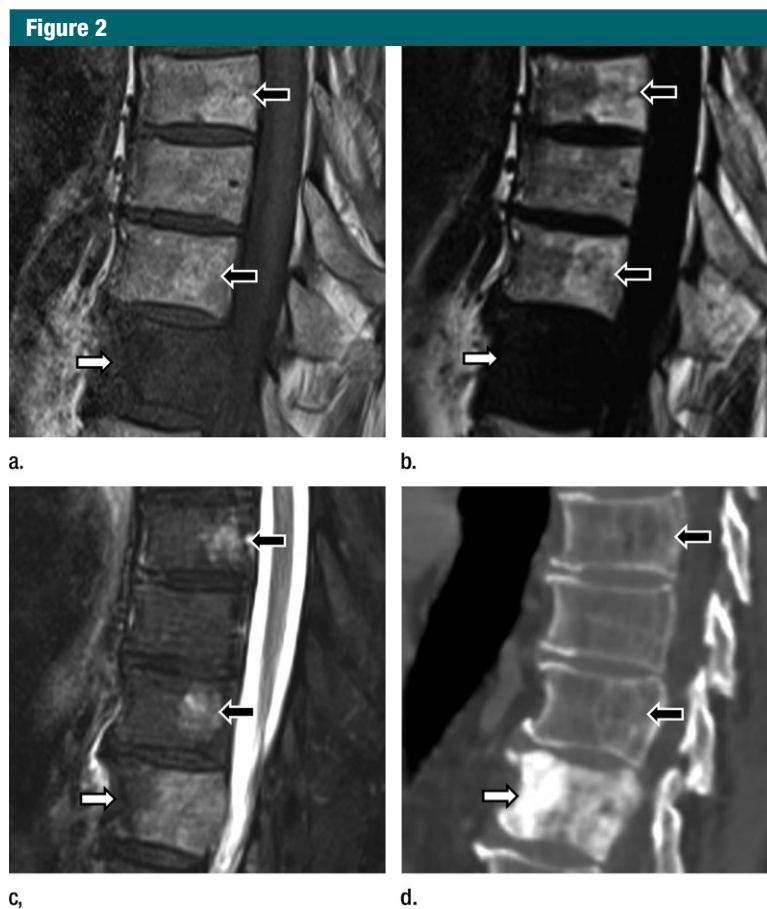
Images in an 81-year-old man with prostate cancer and sclerotic bone metastases. Sagittal thoracic spine MR images include (a) T1-weighted, (b) Dixon T2-weighted fat-only, and (c) Dixon T2-weighted water-only sequences. (d) Unenhanced computed tomographic (CT) image obtained the day after MR imaging, with sagittal reformat, is also shown. Sclerotic metastasis on thoracic spine (white arrow) shows signal intensity slightly hypointense to adjacent paravertebral muscles on a, and no detectable intralésional signal intensity is visible on b. Better conspicuity of lesion on b is supported by higher contrast-to-noise ratio at quantitative analysis (56 for a vs 118 for b). Note two vertebral hemangiomas (black arrows), unchanged over 2 years compared with previous CT images (not shown), with typical thickened trabeculae at CT (black arrows in d), appearing slightly hyperintense relative to normal marrow on a and clearly hyperintense on b image.
